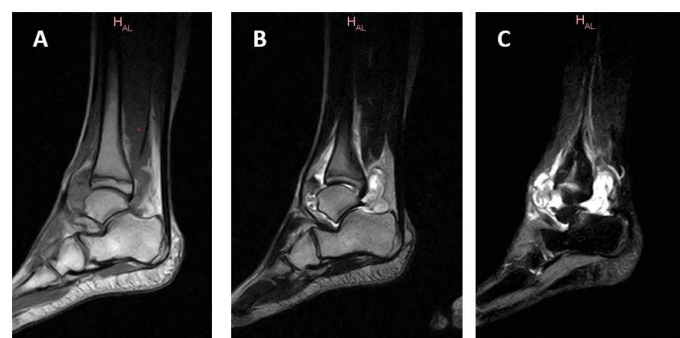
MRI of the right ankle: (A) Proton density fat-sat image showing synovial hypertrophy with nodular lesions (white arrows) in the anterior ankle joint; (B) T2-weighted image showing posterior ankle joint with low-signal deposits (arrowheads) consistent with hemosiderin within hypertrophic synovium (white arrows indicate extent of synovial proliferation).
